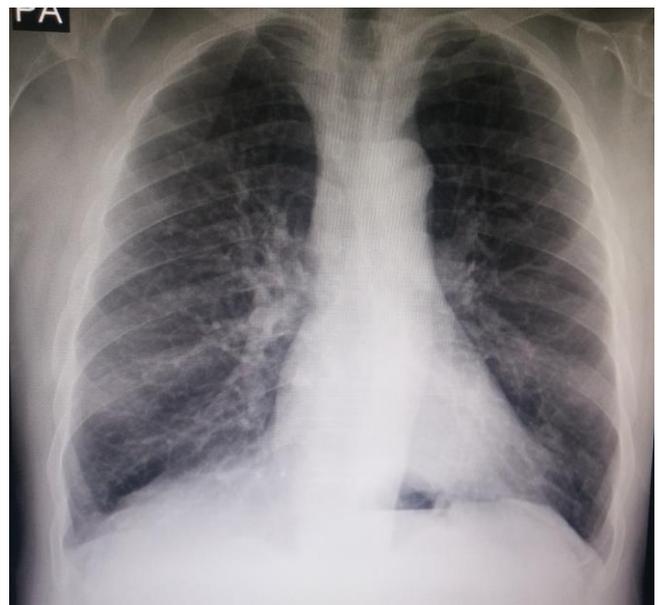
Chest x-ray at admission to hospital
